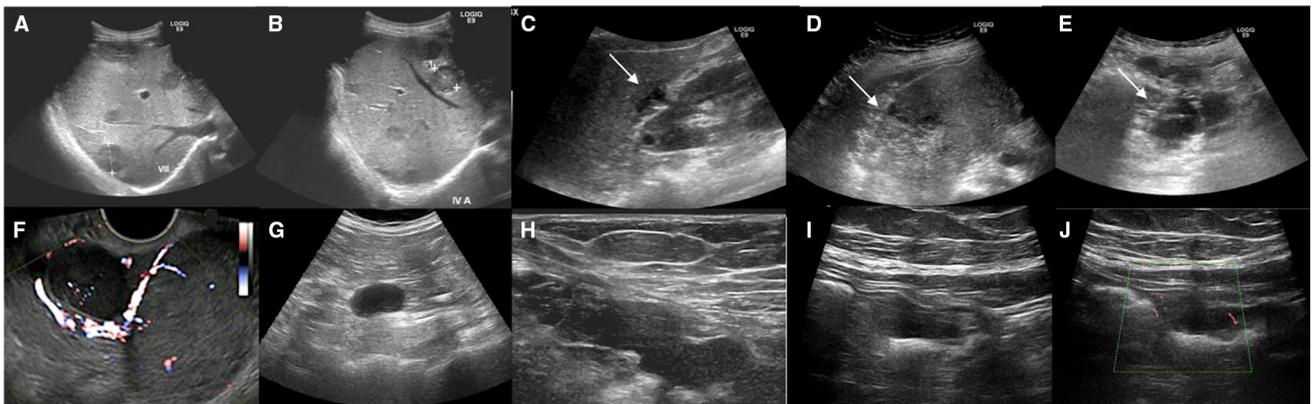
Transabdominal and Endo-vaginal Ultrasound (US) examinations of OC recurrence. A–E show upper abdomen recurrence in a 54 years-old woman; parenchymal hepatic metastasis in VIII and IV segment are shown in A and B; white arrows show glissonian (C, D) and perisplenic (E) implants. F–
